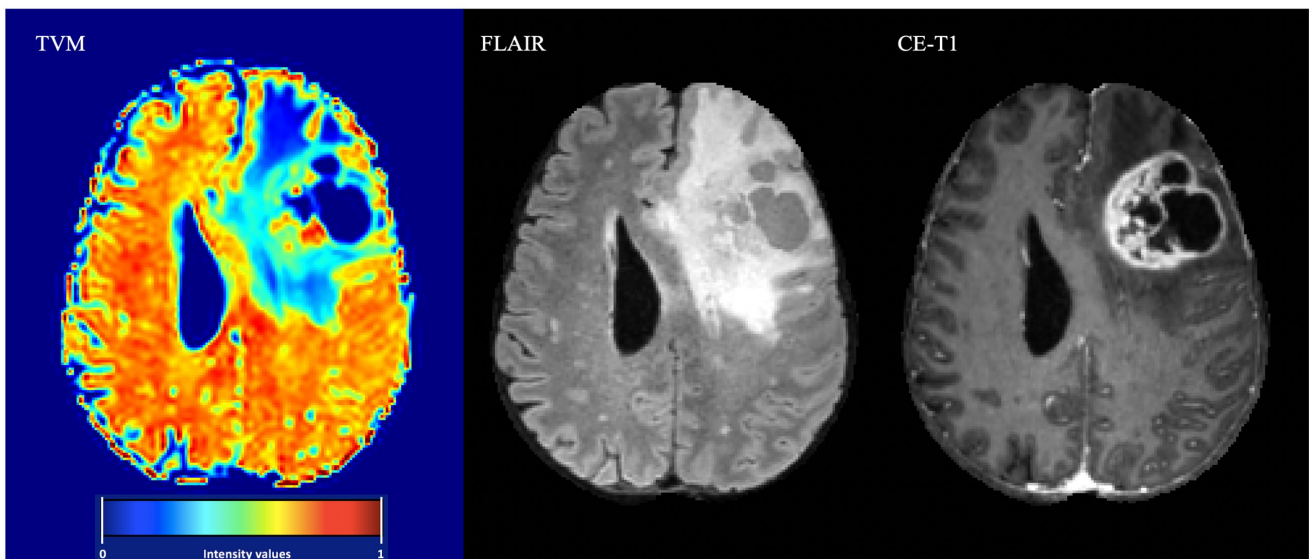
One example of a TVM in a patient with left frontal GBM. Observations are described in the text. A FLAIR and a CE-T1w image of the same slice is added for reference.
